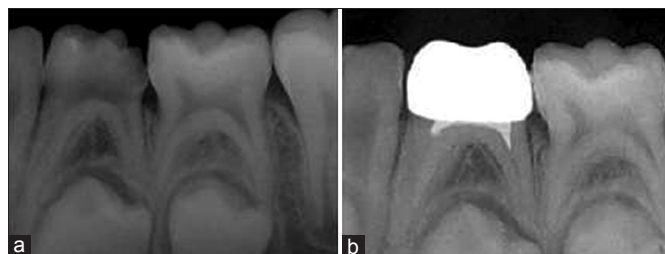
Radiographic features of the teeth treated with *Allium sativum* oil (vital pulpotomy). Mandibular first primary molar showed no changes at 6 months post-operative (b), compared to pre-operative radiograph (a).
